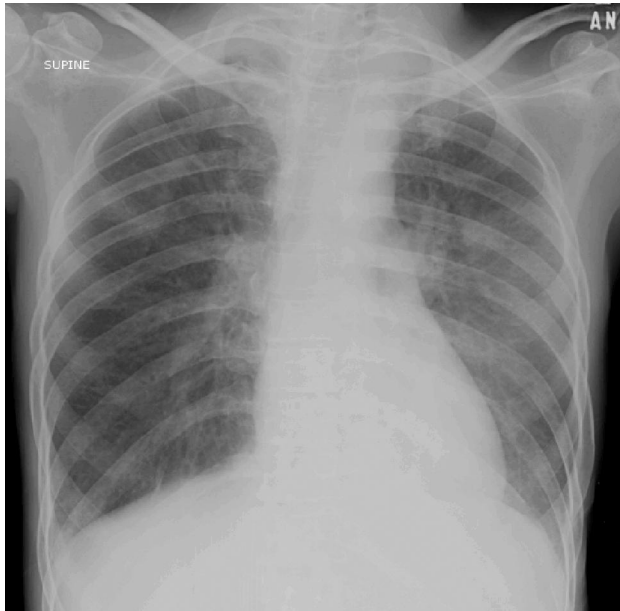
Chest X-ray (PA view): shows an ill defined consolidation involving left upper lung, blunted bilateral costophrenic angles and no evidence of parenchymal calcification
